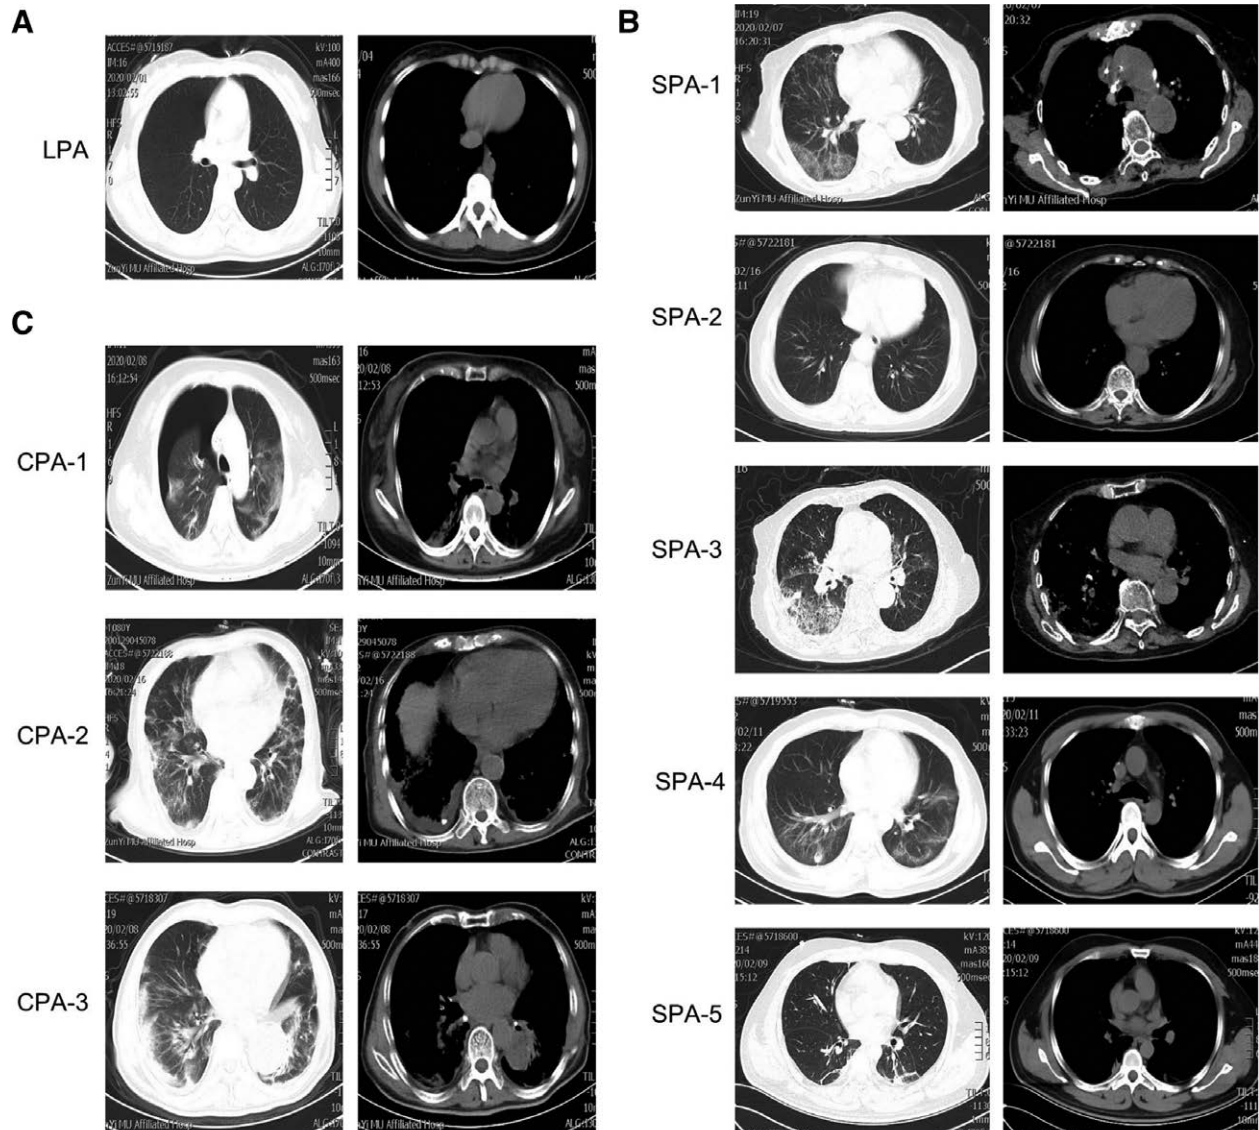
The chest radiographs of 9 patients with COVID-19 infection. (A–C) The chest X-ray images of the patients with COVID-19 infection, including one with mild infection (A), 5 with severe infection (B), and 3 with critical ill infection (C). COVID-19 = Coronavirus Disease 2019.
